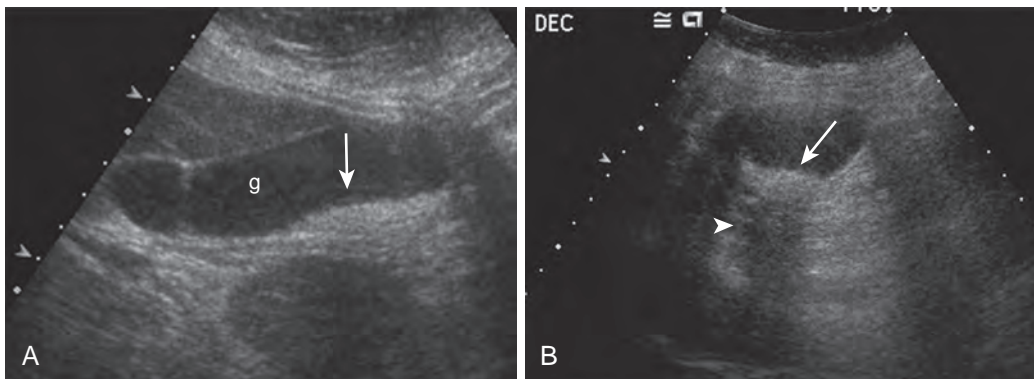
Gravel: sonographic appearance. A. Supine scan of the gallbladder (g) demonstrates echogenic layering material in the lumen (arrow) with no posterior acoustic shadowing. B. In the decubitus position, the material pools in the fundus of the gallbladder (arrow), and a shadow is now demonstrated (arrowhead) consistent with small stones or gravel.
